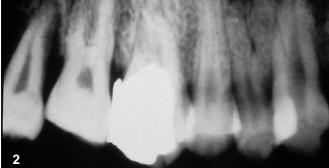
Authentic X-ray digitized with the Kodak digital science photo CD system after photographic reproduction
